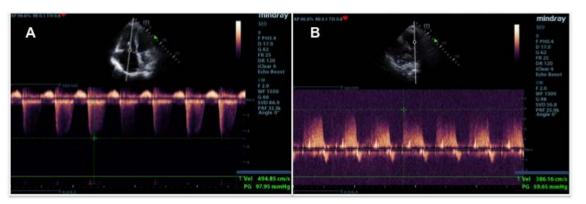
Transthoracic echocardiogram. (A) Using continuous wave—CW Doppler, a maximum tricuspid regurgitation gradient of 98 mm Hg is documented. (B) A maximum gradient of the initial maximum velocity of the pulmonary regurgitation flow of 60 mm Hg is quantified.
